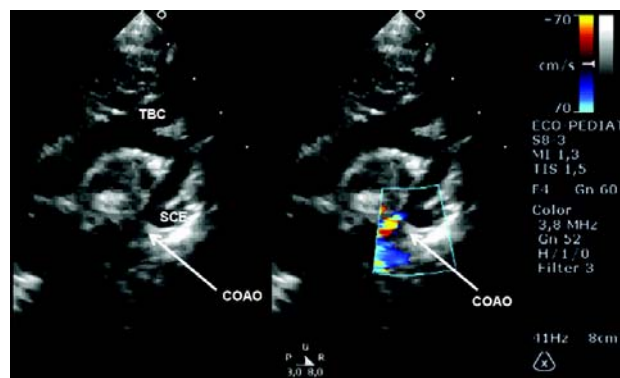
Preoperative echocardiogram. COAO: coarctation of the aorta; TBC: brachiocephalic trunk; SCE: Left subclavian artery
